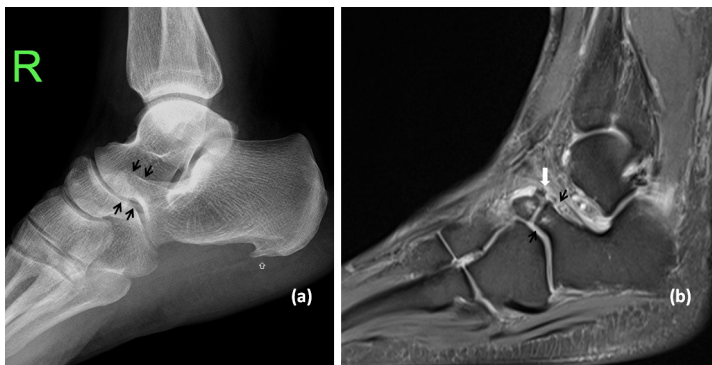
Lateral ankle radiograph (a) and sagittal fat suppressed proton density MR image (b) of a 53-year-old female patient with right ankle pain are presented. Note that the anterior process of the calcaneus that articulates with the navicular bone at the talonavicular coalition (thick white arrow) is elongated (black arrows), mimicking the nose of an anteater. Additionally a plantar calcaneal enthesophyte (white open arrow) is present. MR image shows degenerative changes involving both sides of the coalition (thick white arrow).
